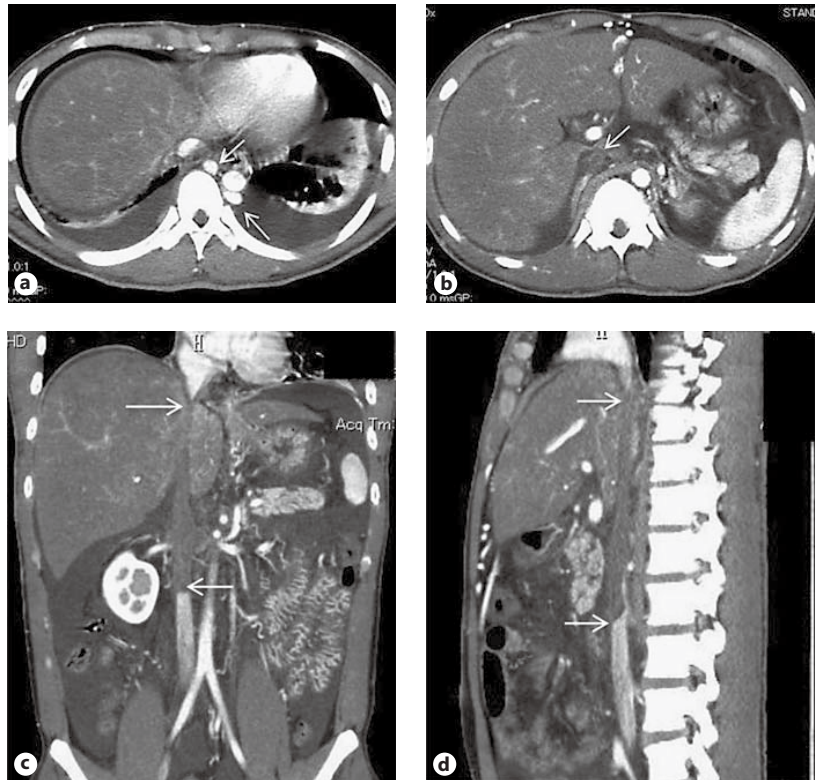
Radiological findings of BCS with complete IVC and HV obstruction (case 3). a CE-CT (portal phase) before the balloon angioplasty; the white arrows indicate dilation of the azygos and hemiazygos veins. IVC obstruction caused by thrombus was detected on axial (b), coronal (c) and sagittal views (d). The white arrows indicate thrombi in the IVC.
